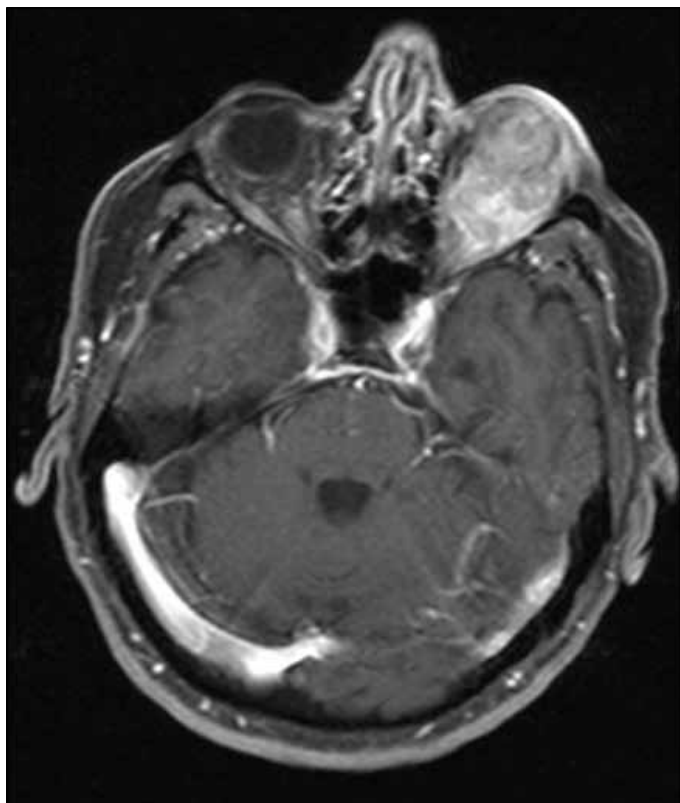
Axial T2-weighted magnetic resonance imaging.
